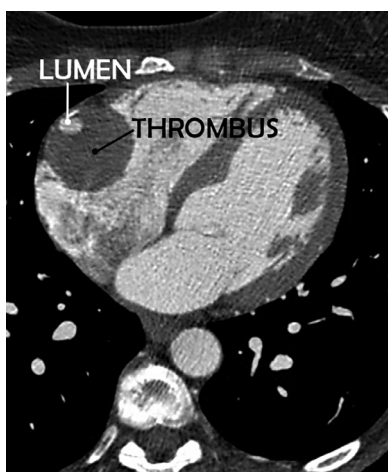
(Case #1, Table 1). Computed tomographic image of the giant RCA aneurysm containing a huge intra-aneurysmal thrombus.
